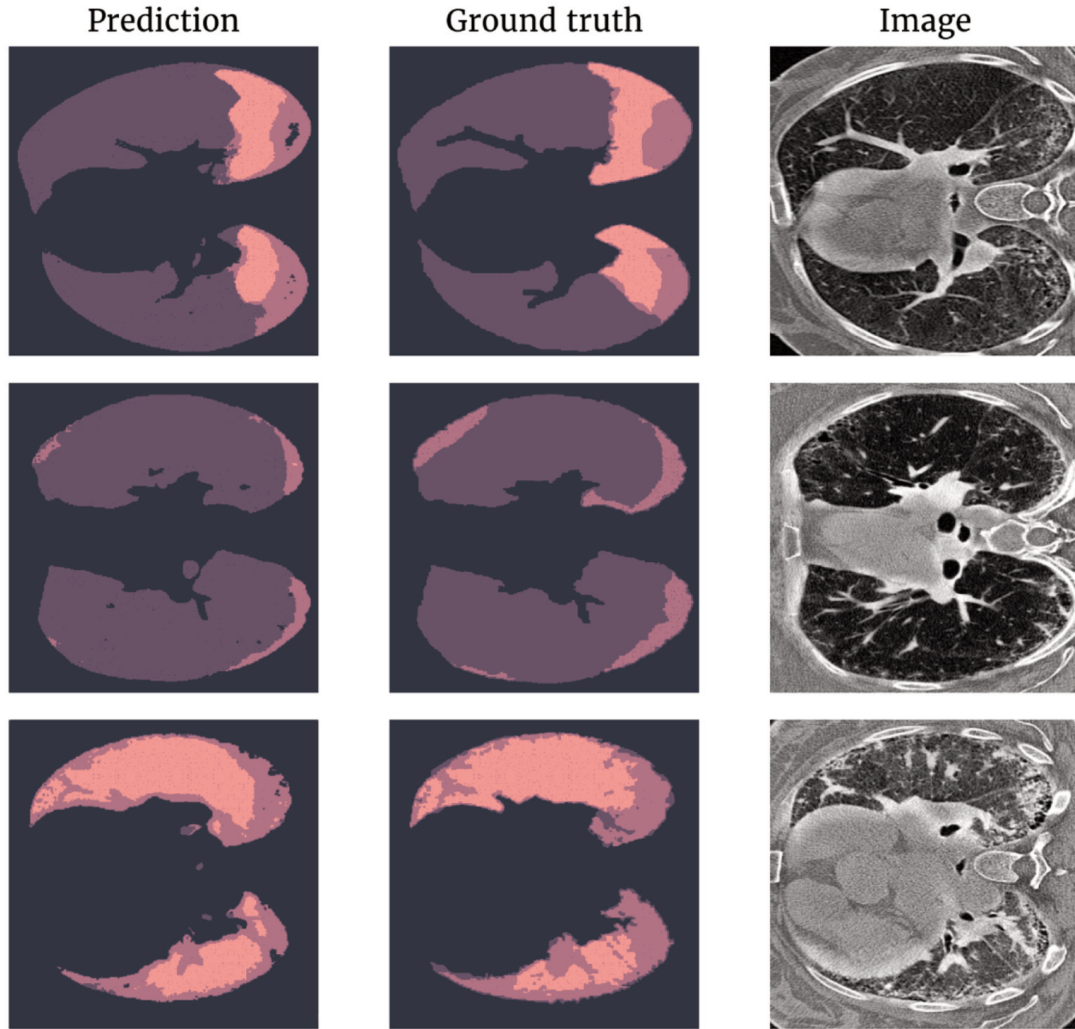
Representative high-resolution computed tomography slices with predicted (left) and ground-truth (middle) segmentations, showing various extents of lesion volume in the dataset. Purple: normal lung; pink: established fibrosis; orange: ground-glass opacity.
